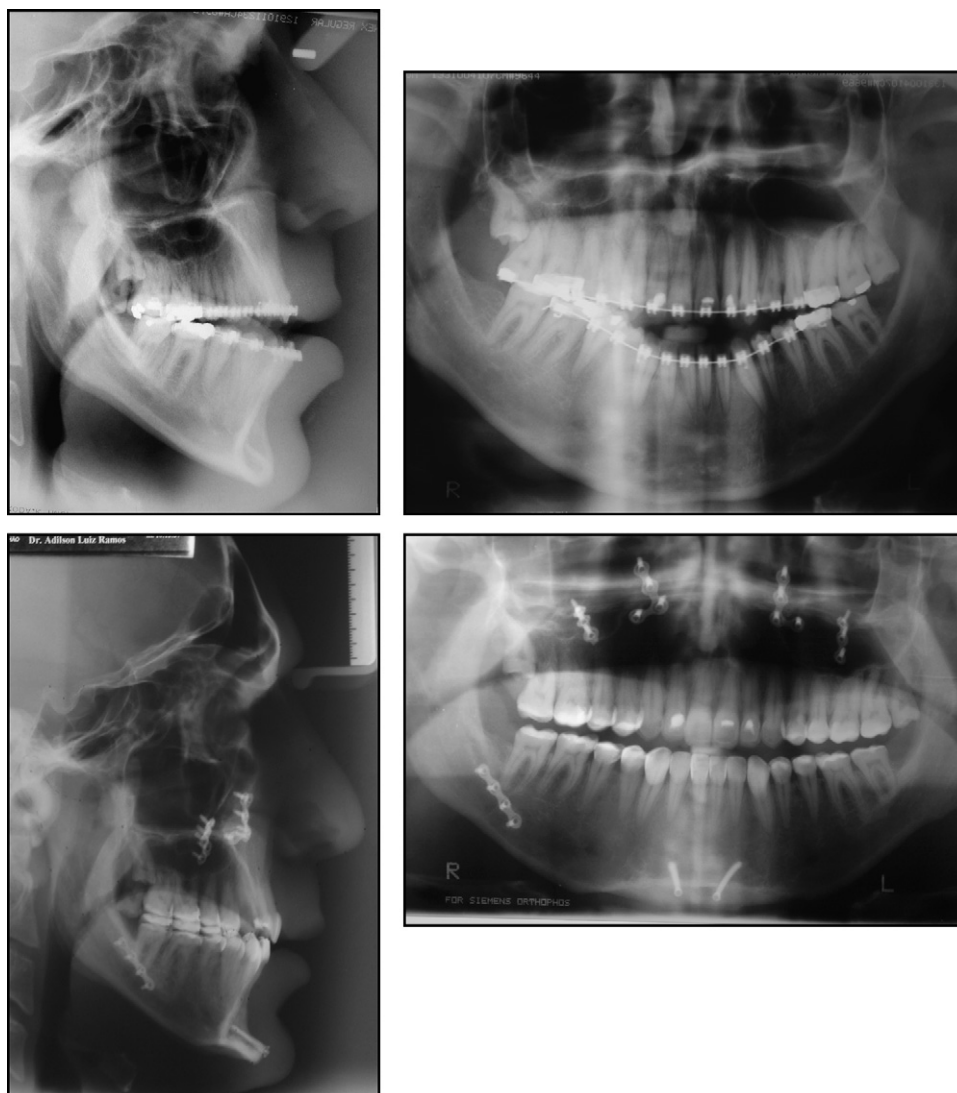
Pre- and postoperative radiographs.
